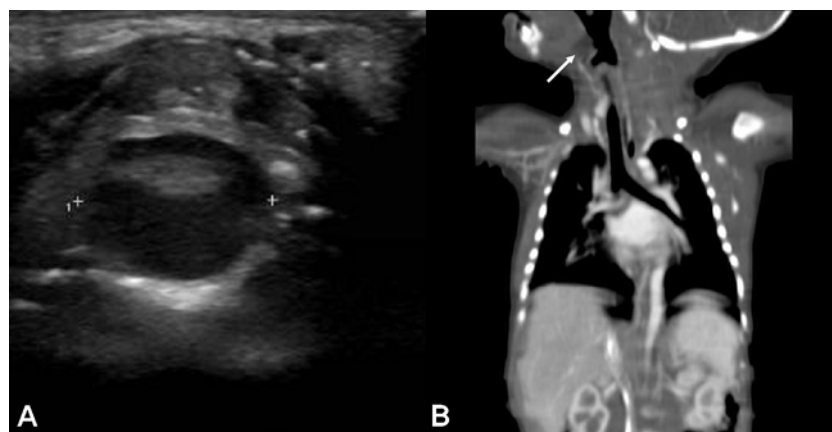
(A) On ultrasonography, a 1.3×1.1×1.1 cm sized mass and unilocular cyst were located at the base of the mouth. (B) The CT film taken at the other hospital also showed the cystic mass, suggesting a vallecular cyst.
